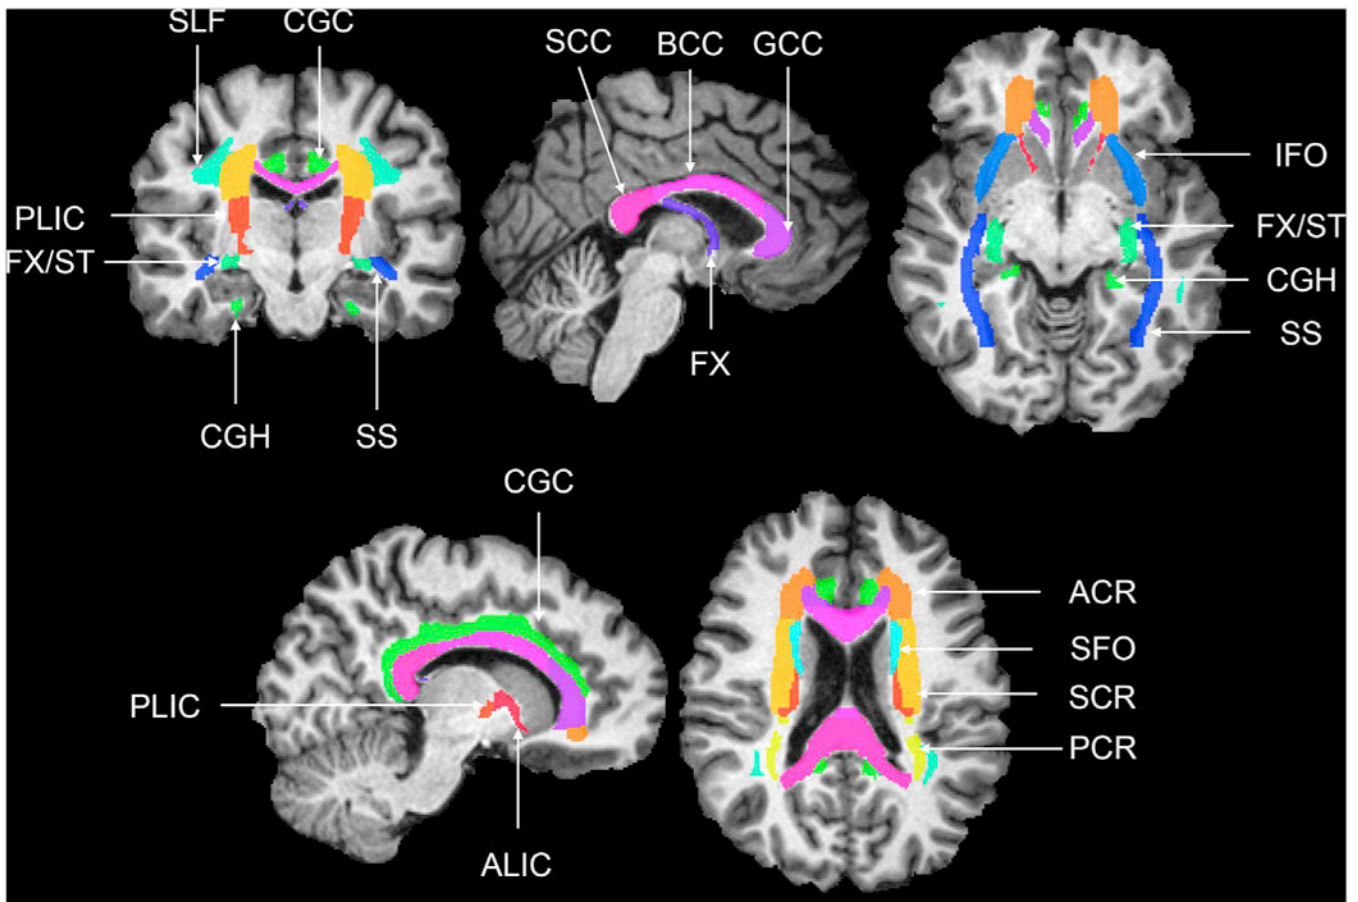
Coronal, axial and sagittal slices showing the Eve white matter ROIs (Mori et al., 2008a,b) overlaid on a T1-weighted image. anterior corona radiata (ACR), anterior limb of the internal capsule (ALIC), body of the corpus callosum (BCC), cingulum gyrus (CGC), cingulum (hippocampus) (CGH), column and body of the fornix (FX), fornix/stria terminalis (FX/ST), genu of the corpus callosum (GCC), inferior fronto-occipital fasciculus (IFO), posterior corona radiata (PCR), posterior limb of the internal capsule (PLIC), corpus callosum (SCC), superior corona radiata (SCR), superior fronto-occipital fasciculus (SFO), Superior longitudinal fasciculus (SLF), sagittal stratum (SS).
